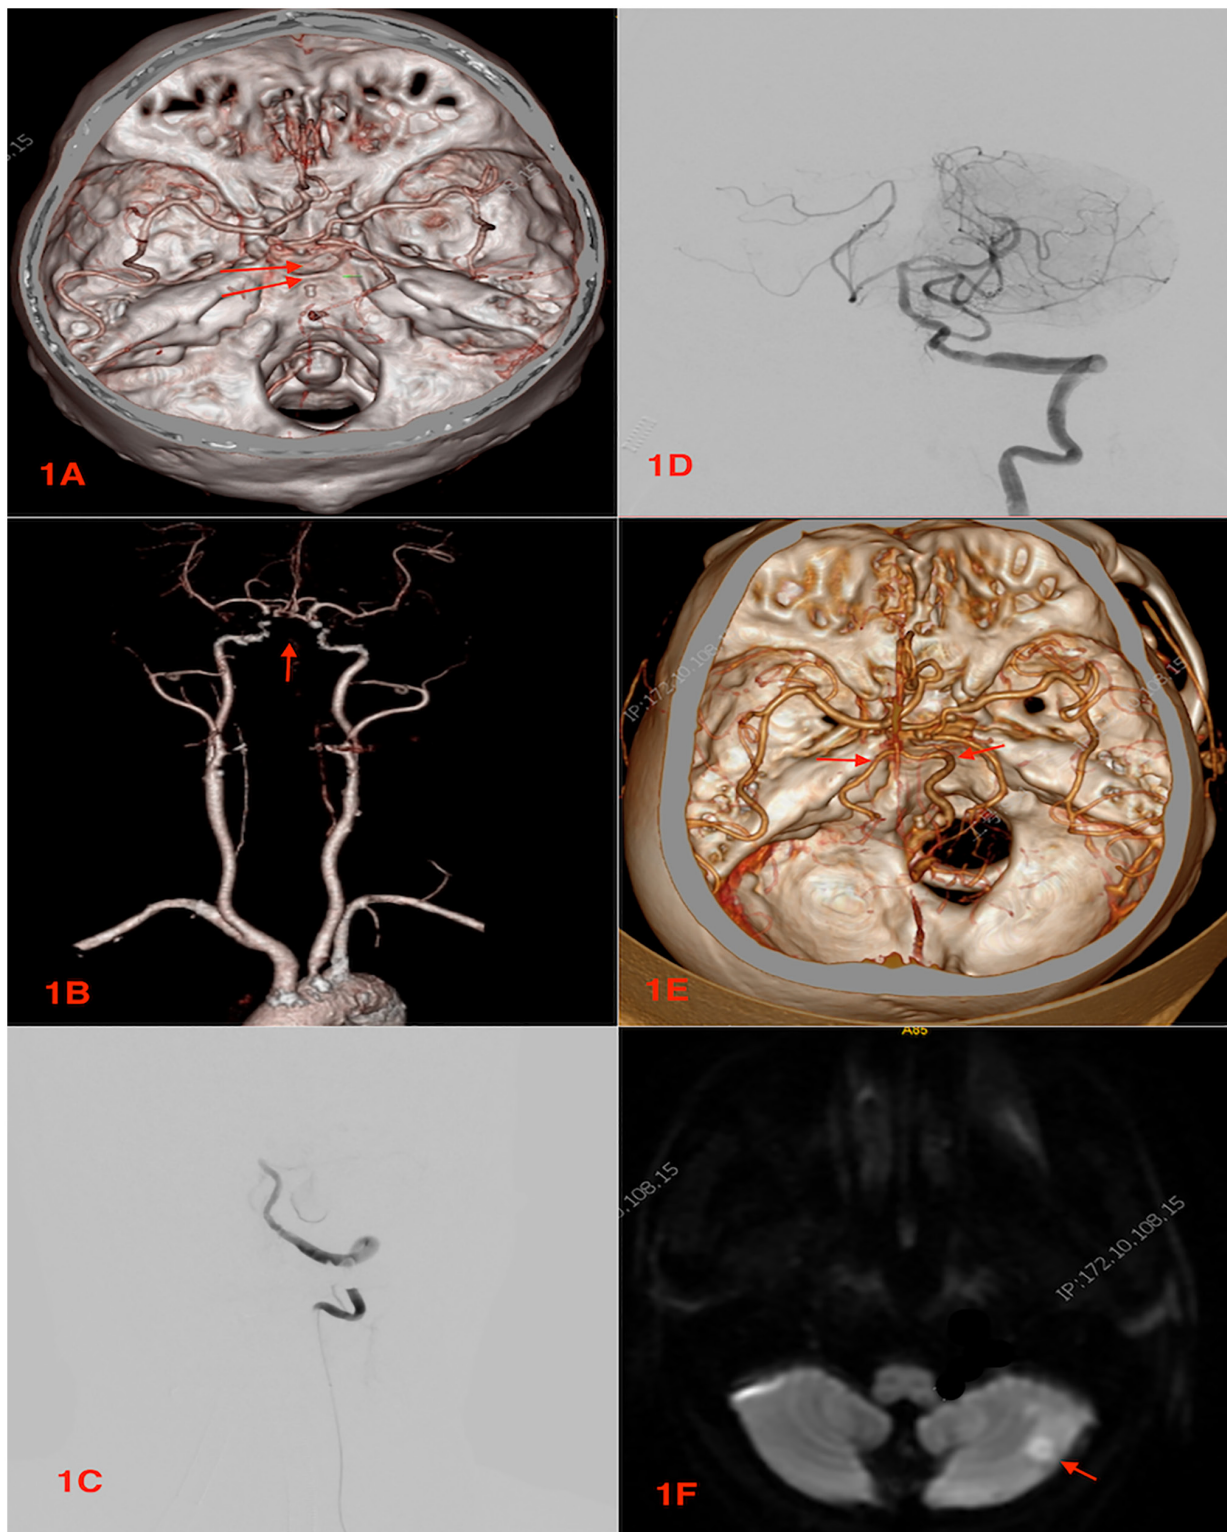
Images of one of the patients in the present study who underwent mechanical thrombectomy for basilar artery occlusion. (A-F) Pre-, intra- and post-operative images of the patient. (A and B) Pre-operative CTA images now showing no basilar artery. Red arrow indicates no basilar artery. (C) Intraoperative digital subtraction angiography showing the acute occlusion of the basilar artery. (D) Intraoperative digital subtraction angiography following thrombectomy showing the recanalization of the basilar artery. (E) Post-operative CTA showing the recanalized basilar artery. Red arrows indicate the basilar artery. (F) Post-operative magnetic resonance imaging showing an acute infarct in the cerebellar hemisphere. Red arrow indicates the infarction. CTA, computer tomographic angiography.
